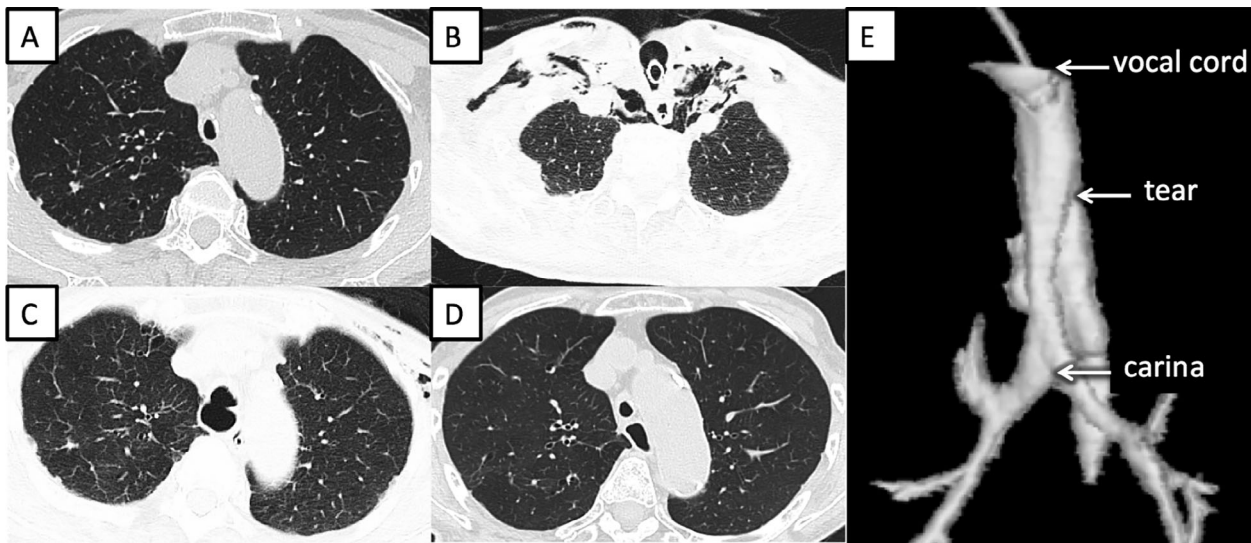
Chest computed tomography (CT). (A) CT revealed a tracheal stenosis with wall thickening before tracheostomy. (B) Mediastinal emphysema developed one month after tracheostomy. (C) A tracheal membrane tear was observed on admission to our hospital. (D) Three months later, the tracheo-mediastinal fistula closed naturally. (E) 3D-CT revealed tracheo-mediastinal fistula.
